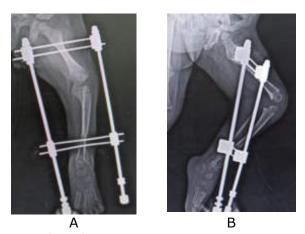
A & B - Post op x-ray
